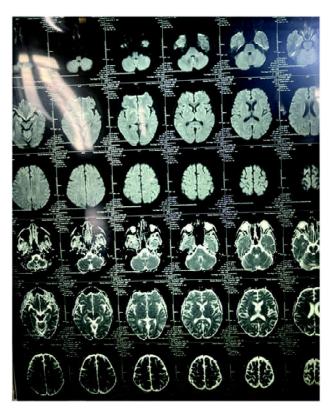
MRI brain: Axial view.
